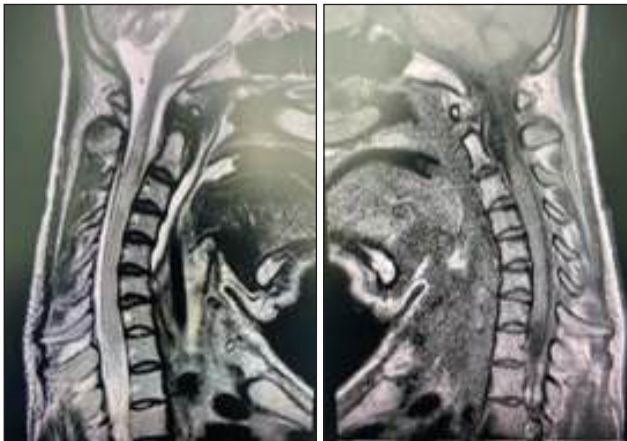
Cervical MRI showing spinal cord edema and signal changes.
